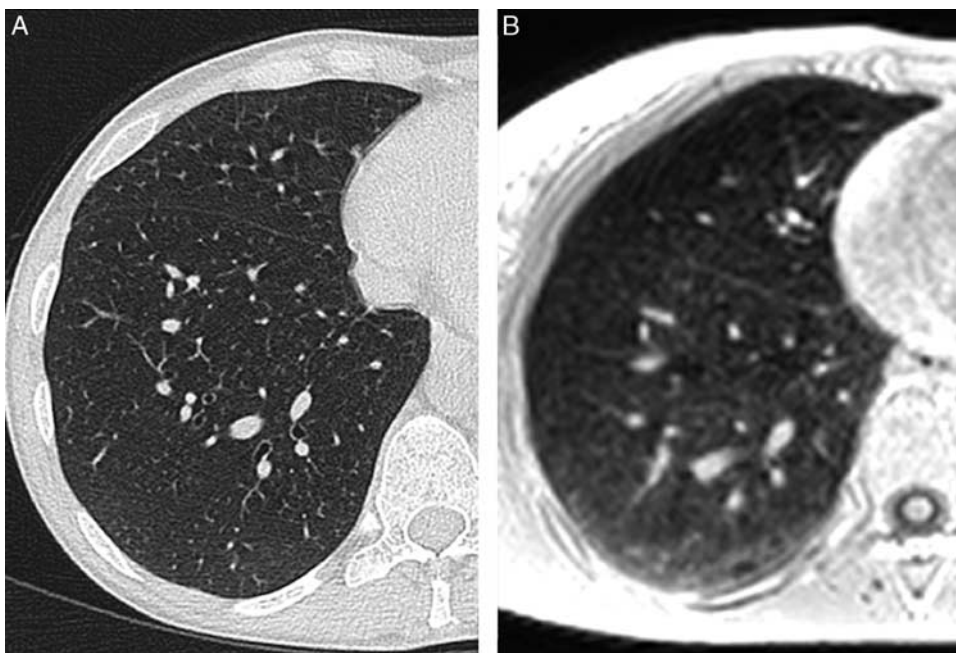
SSc-ILD, right lung: possible cause of disagreement in ILD detection on UTE. If ILD is absent or mild on CT (A), ground-glass opacities on UTE (B) could be entirely interpreted as dependent atelectasis or ILD.
